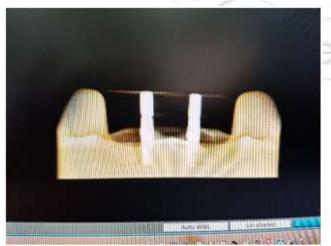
CBCT to the implant and parallel guide
